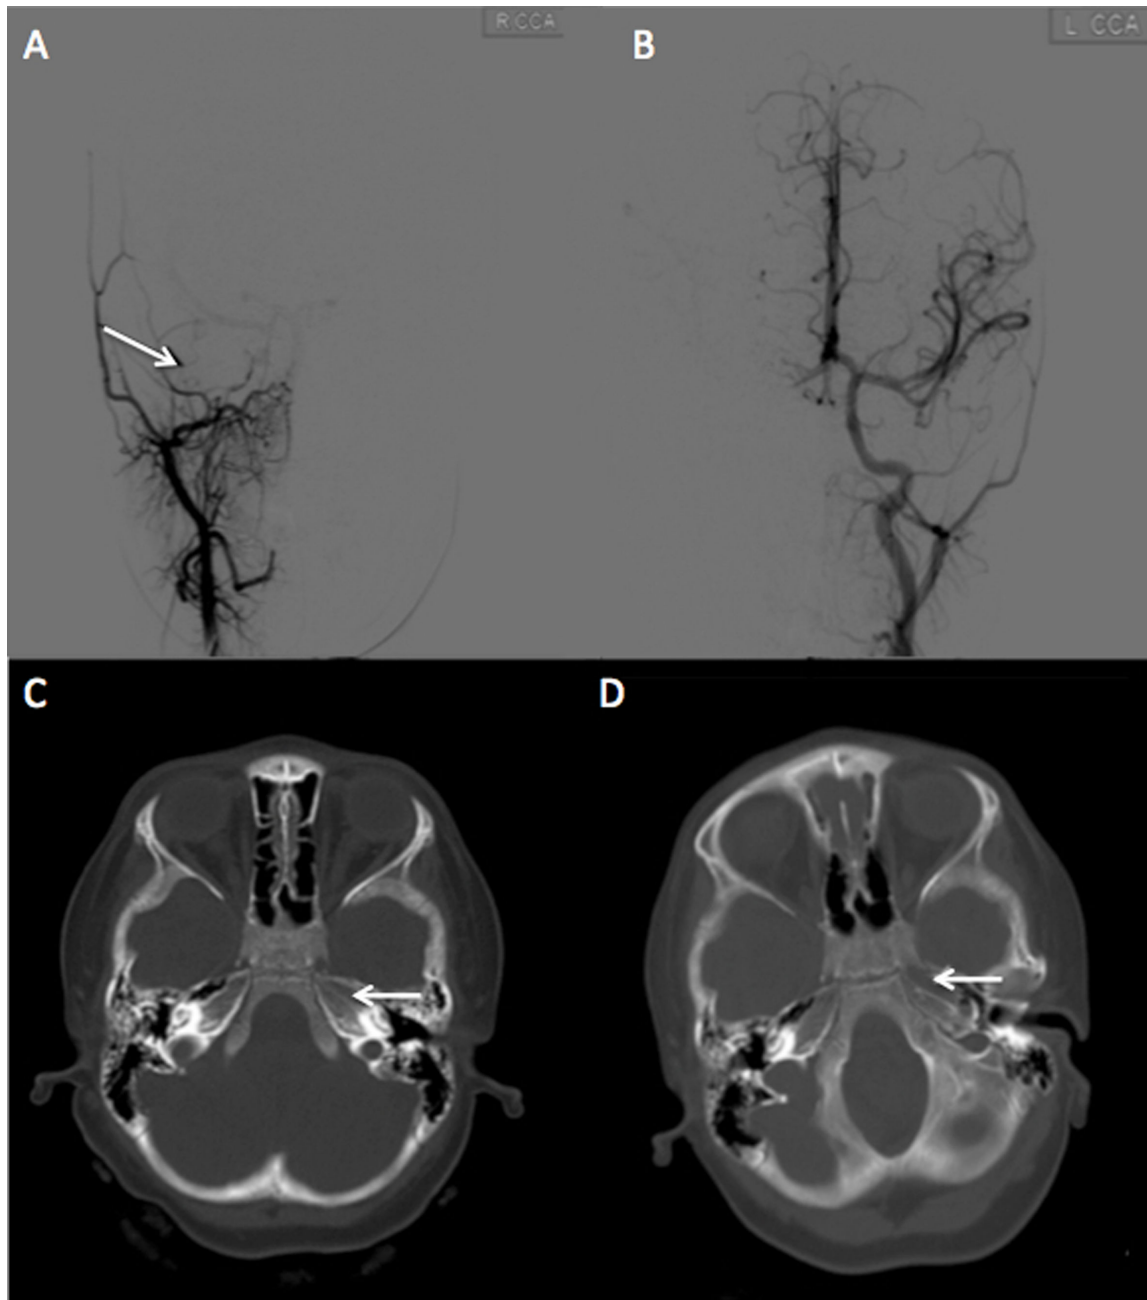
Aplasia of right internal carotid artery. Panel a shows right common carotid angiography anteroposterior view, demonstrating the absence of the right ICA. the CCA solely supplies the ECA and its branches. the left carotid injection (Panel B) demonstrates cross-flow across the anterior communicating artery to the contralateral side. Therefore, the right anterior cerebral artery is obvious almost through its entire extent. Panels C and D are CT head (bone windows), axial section. the hypoplasia of right carotid canal is obvious when compared with its normal counterpart (arrow).
